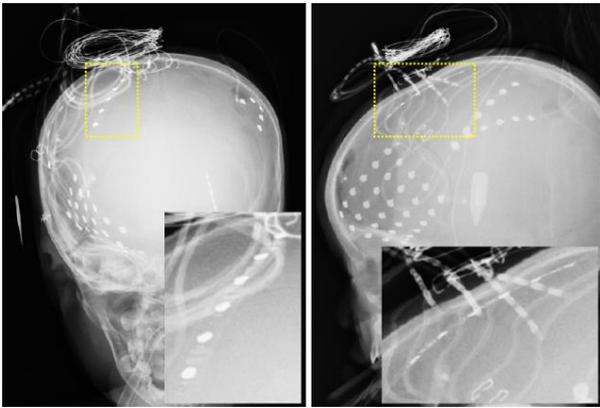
X-ray images after the electrode implantation surgery. Subdural electrodes were installed around the epileptic focus in right frontal lobe for diagnosis. The proposed probe was placed at the right temporal area to avoid interfere with the diagnosis. The area around the proposed probe is indicated by the yellow dotted square and magnified.
